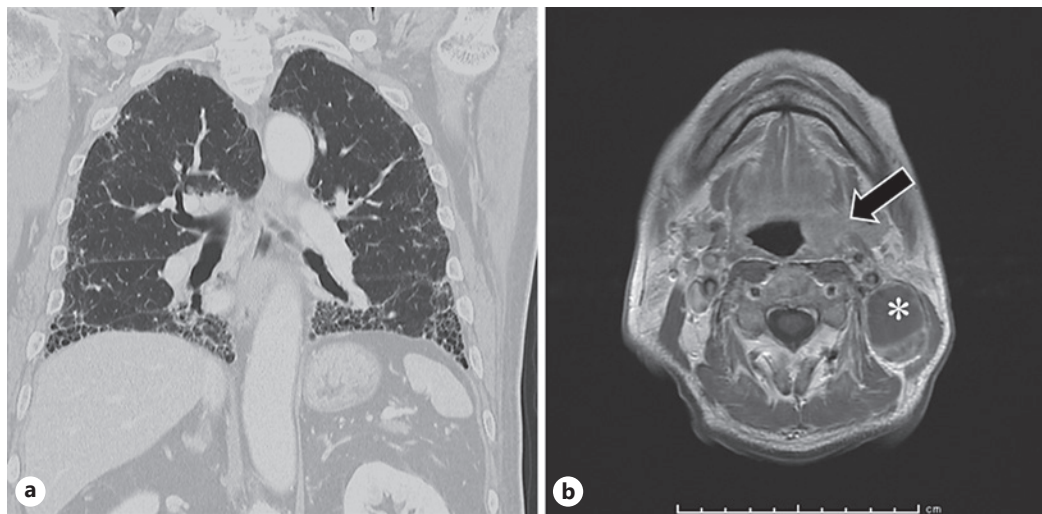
Pre-treatment images of oropharyngeal carcinoma. a CT image of severe idiopathic pulmonary fibrosis (IPF). Contrast-enhanced T1-weighted fast spin-echo MR imaging (b) shows the primary tumor (arrow) and the bulky lymph node metastasis (asterisk).
